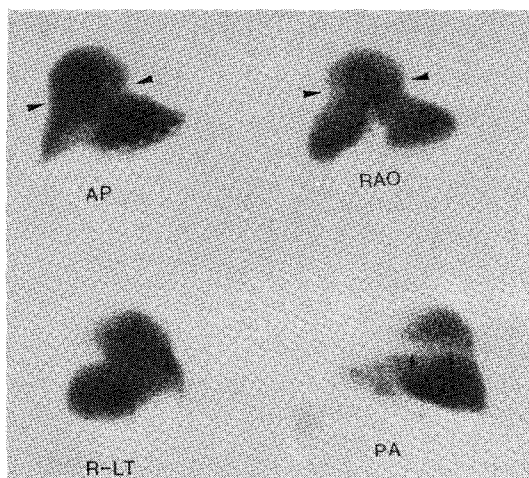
Hepatic scintigram showing a superior bulge with a ring constriction of the right hepatic lobe on AP and RAO images (arrow heads). There is a band-like photon defect at the neck of the superior bulge on posterior image (arrows).
